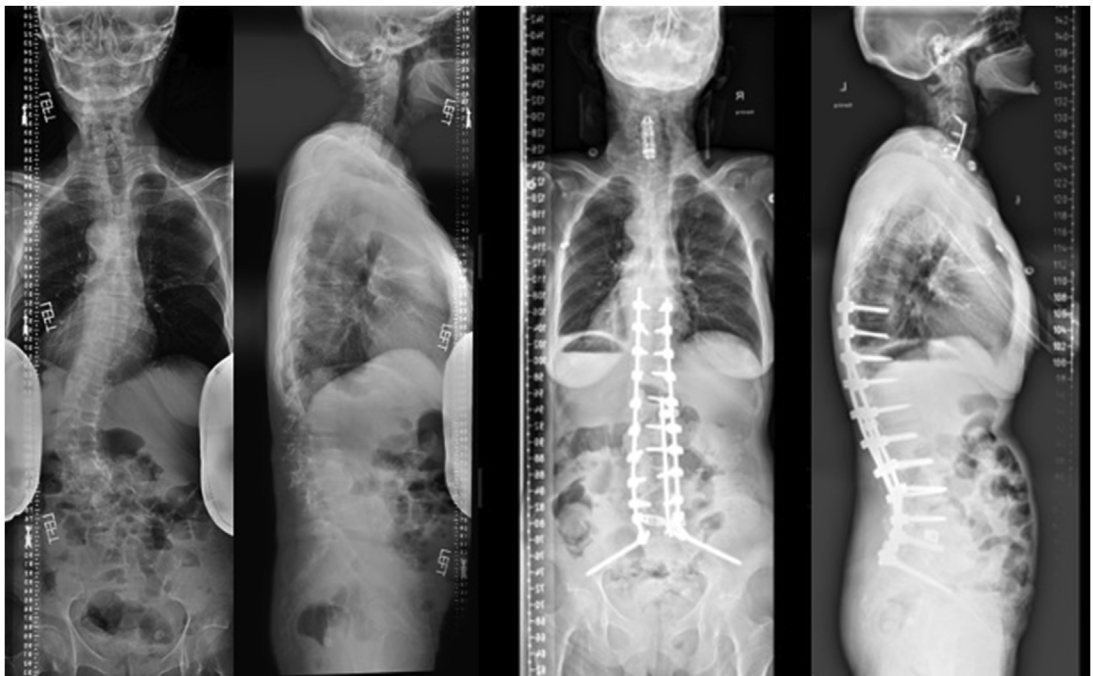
This is a 66-year-old woman with scoliosis and severe back pain. She had preoperative coronal malalignment with lumbar hypolordosis. Preoperative AP and lateral radiographs (left) demonstrate coronal vertical axis 3.0 cm, sagittal vertical axis 4.2 cm, pelvic incidence-lumbar lordosis mismatch 40 to 5°, and pelvic tilt 20°. She underwent a T9 to pelvis posterior instrumented fusion with L1-S1 posterior column osteotomies, and L5-S1 TLIF. Three-year postoperative AP and lateral radiographs (right) show excellent correction of her coronal alignment while re-establishing her physiologic lumbar lordosis and maintaining her sagittal alignment (cervical vertical axis 0.8 cm, sagittal vertical axis 2.0 cm, pelvic incidence-lumbar lordosis mismatch 40–31°: 9, pelvic tilt 19°).
